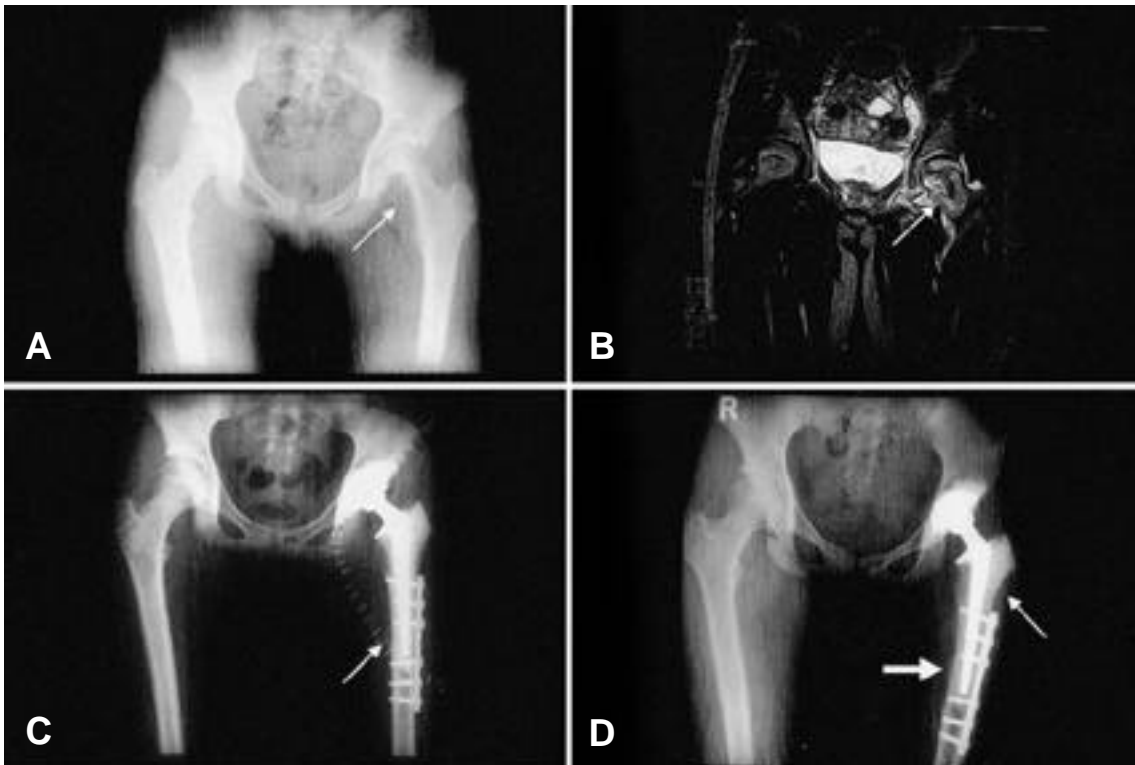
A 13-year-old girl had osteoblastic osteosarcoma of the femoral head and neck. (A) A preoperative plain radiograph shows a radiolucent lesion (arrow) on the inferomedial aspect of the femoral head and neck. (B) A T2-weighted coronal magnetic resonance image shows invasion of the hip by a tumor mass (white arrow). (C) A postoperative radiograph shows the reconstruction of the hip with total hip arthroplasty after extraarticular excision, and the osteotomy site (white arrow) (D) A plain radiograph obtained at the 42-month followup shows a solid bony union (large white arrow). New bone formation was found on the lateral aspect of the low heat treated bone (small white arrow).
